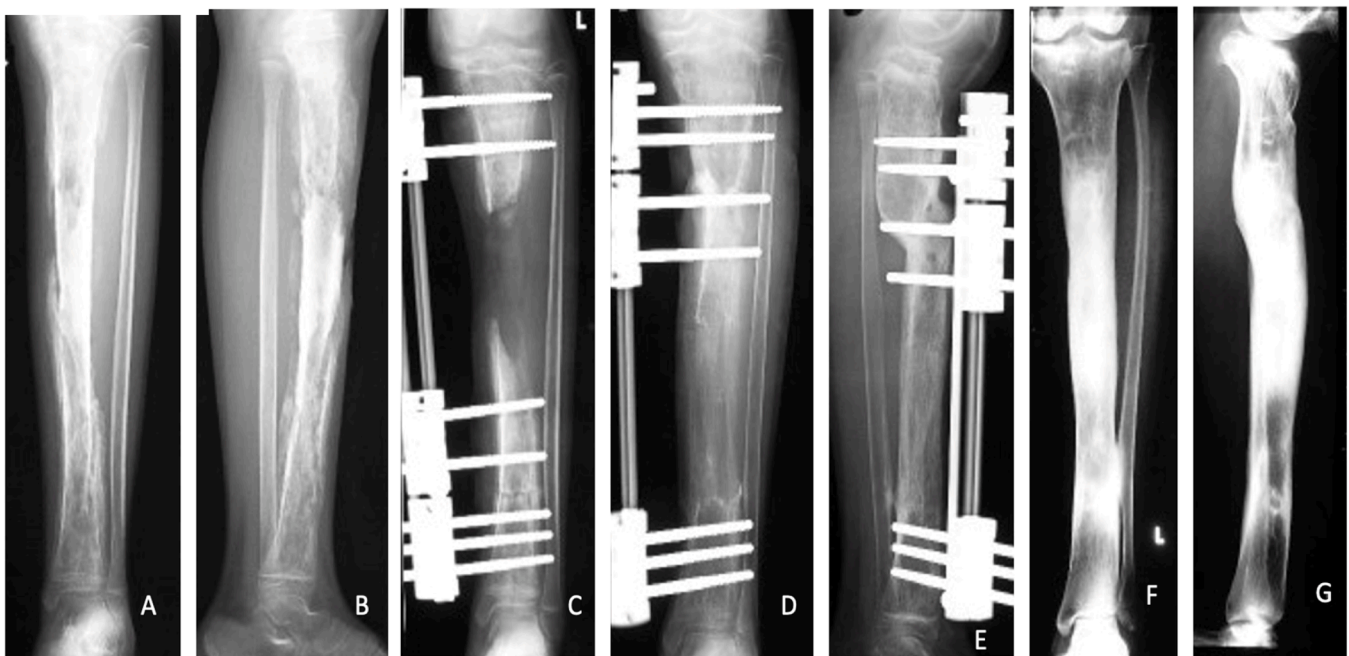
X-ray series of a complicated case of a chronic osteomyelitis of the left tibia in a 10 years old girl, whose onset was apparently 5 months prior to presentation. X-rays showed a large sequestrum of the tibial midshaft with only minor involucrum formation (A and B). No further involucrum formation can be expected after such a long time from the onset of the disease. The local conditions were good and allowed for sequestrectomy and debridement with additional application of an Orthofix Rail fixator for a bone-segment-transport procedure with a corticotomy at the distal tibial shaft (C). After 8 months, there was a full bony regeneration of the former bone defect area with successful docking of the transported segment to the proximal tibia (D and E). Latest X-ray follow up after another 6 years showed excellent bone remodeling of the tibia in correct axis without any signs of reinfection (F and G).
